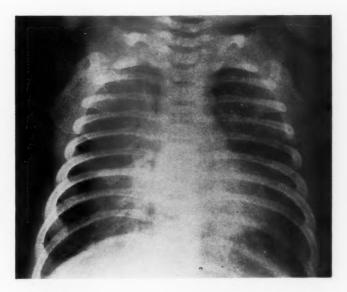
Case 1.—Roentgenogram of the chest made on the eighteenth day after admission. It shows bilateral emphysema, infiltration in the left base and a triangular density of the right base. Bronchoscopic examination was done on this patient four days later.
